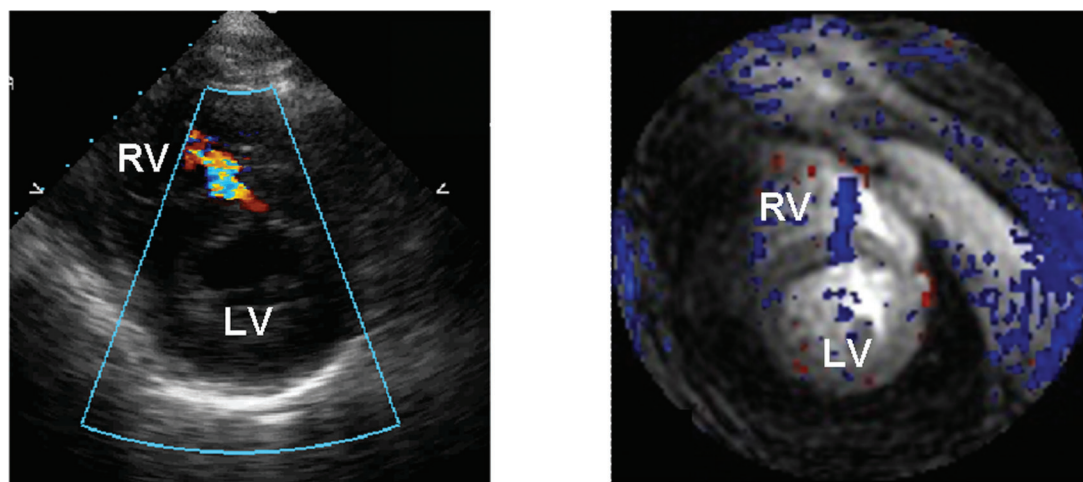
Muscular VSD. Short-axis views from echocardiography and real-time color-flow CMR of a muscular VSD with shunting from the left ventricle (LV) to the right ventricle (RV). Note that the CMR image plane has been adjusted to align the flow jet and there is no aliasing. Supplemental material is available for this figure. Go to the publisher's online edition of *JCMR* for the right image as a movie clip.
